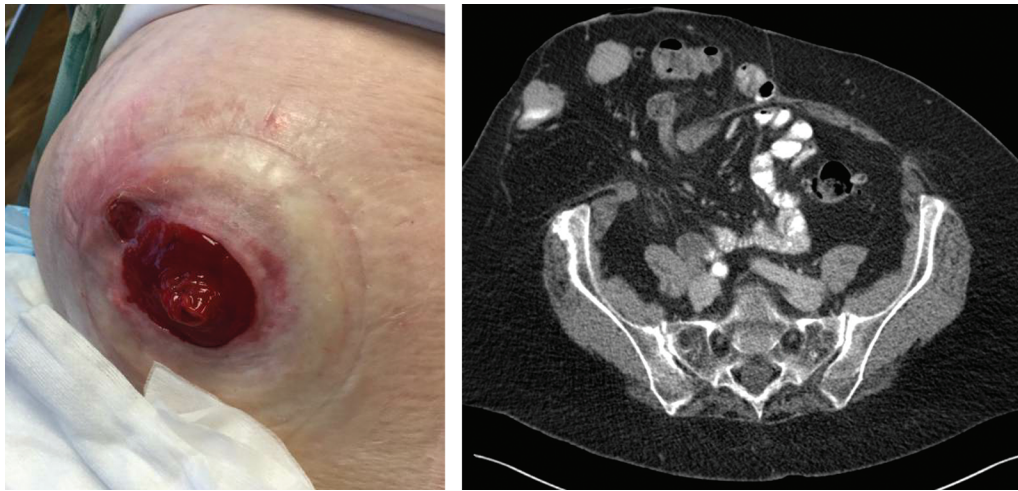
Clinical (left) and radiographic (right) appearance of large parastomal hernia containing bowel.
